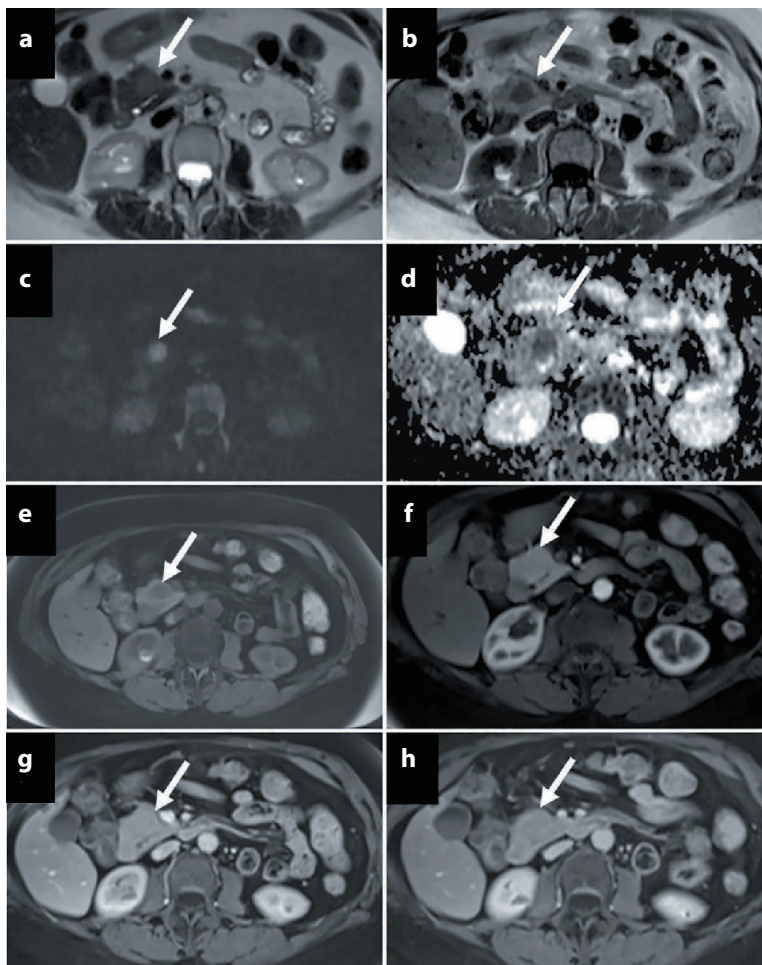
Malignant non-functioning P-NET in a 70-year-old woman presenting with vague abdominal pain. Lesion located in the pancreatic head (17 mm) appears slightly hyperintense on axial T2-weighted MRI (a) and hypointense on axial T1-weighted imaging (b) (arrow). On the diffusion-weighted image (c) and ADC map (d) the tumor shows hypercellularity with appreciable restriction of the movement of the water molecules. On dynamic contrast-enhanced fat-suppressed T1-weighted images, acquired before contrast media administration (e), during the arterial (f), portal (g) and equilibrium (h) phases, the tumor appears isointense to the surrounding parenchyma, without showing any hypervascular behavior
